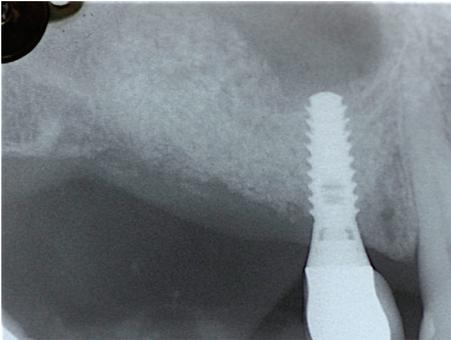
Radiograph 6 months after surgery.
